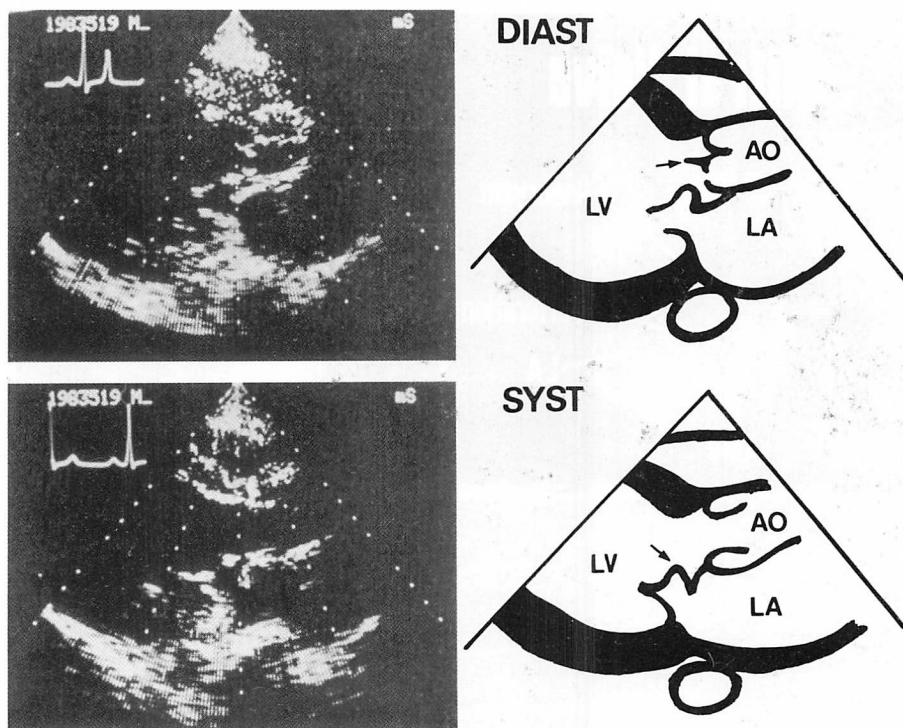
Parasternal long-axis views of two-dimensional echocardiograms (Case 1).
